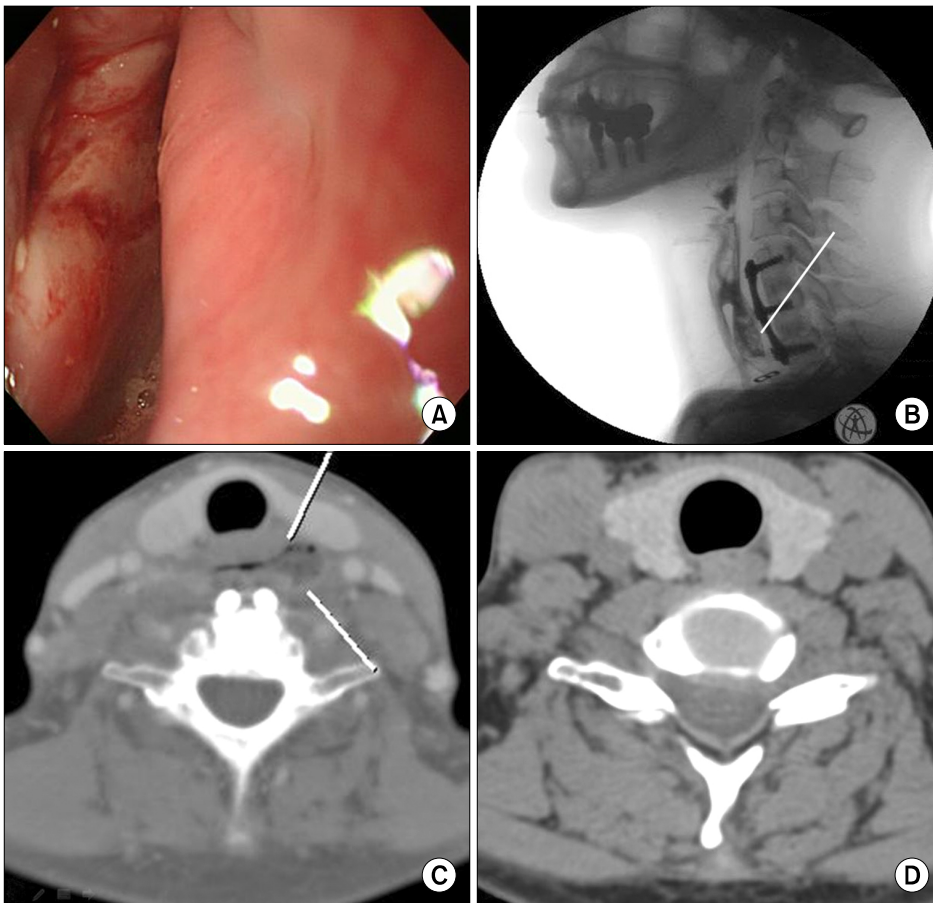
(A) Endoscopy and (B) video-fluoroscopic swallow study showed a diverticulum. (C) Preoperative neck CT reveals a 2.5-cm pouch with communication with the esophageal lumen. (D) Pre-anterior cervical discectomy and fusion neck CT shows no finding consistent with a Zenker diverticulum. CT, computed tomography.
